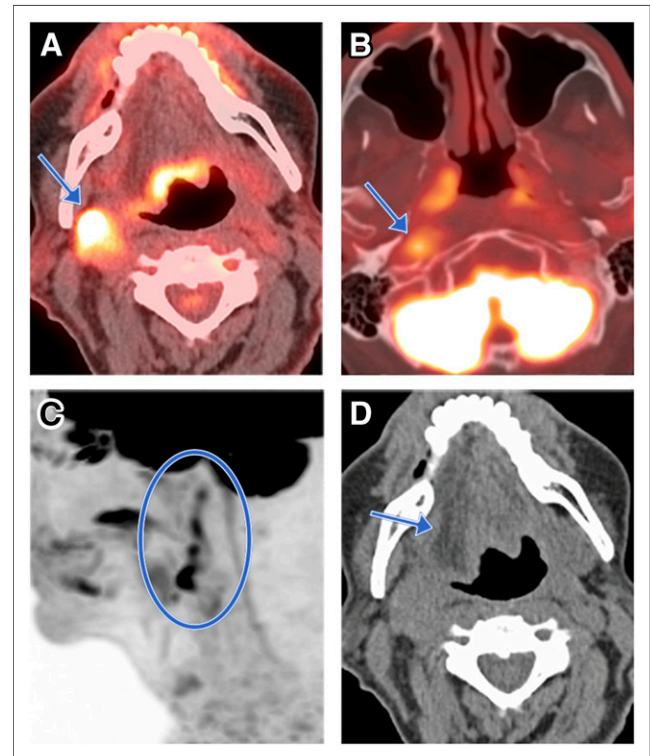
CN XII involvement in patient with stage IV metastatic squamous cell carcinoma from unknown primary, presenting with dysphagia and slurred speech. (A and B) Axial PET/CT images show ^{18}F -FDG-avid metastatic tumor in right carotid space (arrow) (A) and ^{18}F -FDG-avid perineural tumor spread along right CN XII superiorly to base of skull just inferior to hypoglossal canal (B). (C) Sagittal maximum-intensity-projection PET image shows course of perineural tumor spread (circle). (D) Axial CT image shows ipsilateral right tongue atrophy with fatty infiltration (arrow) secondary to CN XII palsy. Patient subsequently received palliative radiation therapy of neck mass.
